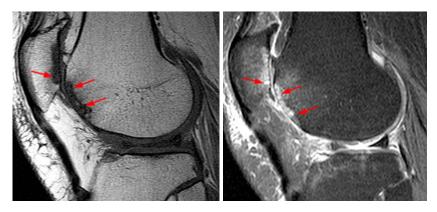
Bone marrow lesions on T1-weighted (left) and STIR (right) MRI scans.
